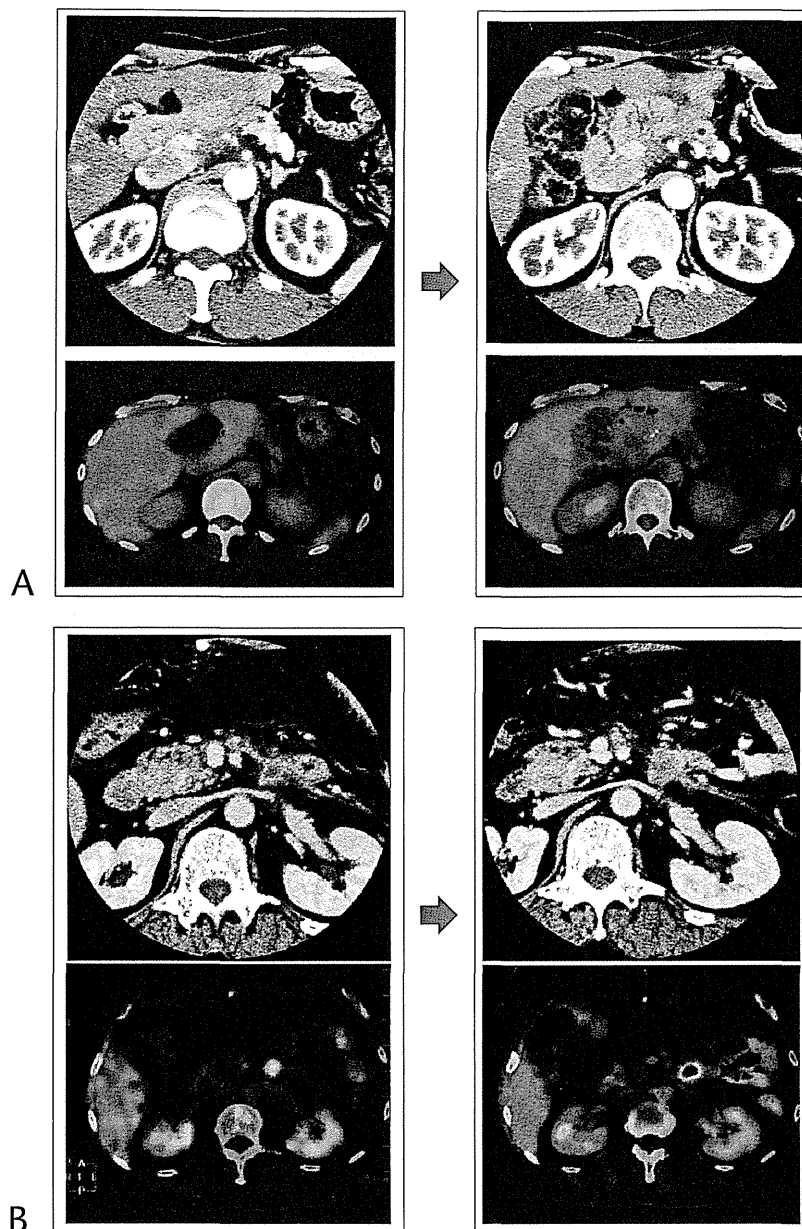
Positron emission tomography/contrast-enhanced CT findings of 2 typical cases, 1 with “local recurrence” and the other with “no local recurrence,” are shown. A, A 46-year-old man with no local recurrence (false-positive by CE-CT and true-negative by PET/CE-CT). The CE-CT image, which was performed 17 months after surgery, showed a soft tissue density mass, which did not rule out local recurrence (left upper panel, arrow). However, the PET/CT image did not show FDG uptake corresponding to this mass, suggesting no local recurrence (left lower panel, arrow). A follow-up PET/CE-CT image, which was performed 8 months after the initial examination, revealed no increase in the size and FDG uptake of the mass (right panel, arrow), indicating that the initial diagnosis of no local recurrence by PET/CE-CT was correct. B, A 59-year-old man with local recurrence (true-positive by CE-CT and PET/CE-CT). The CE-CT image, which was performed 3 months after surgery, showed a soft tissue density mass, which did not rule out local recurrence (left upper panel, arrow). The PET/CT image shows abnormal FDG uptake (SUV_{max} , 4.73) corresponding to this mass, suggesting local recurrence (left lower panel, arrow). A follow-up PET/CE-CT image, which was performed 3 months after the initial examination, revealed an increase in the size and FDG uptake (SUV_{max} , 6.99) of the mass (right panel, arrow), indicating that the initial diagnosis of local recurrence by PET/CE-CT was correct.
